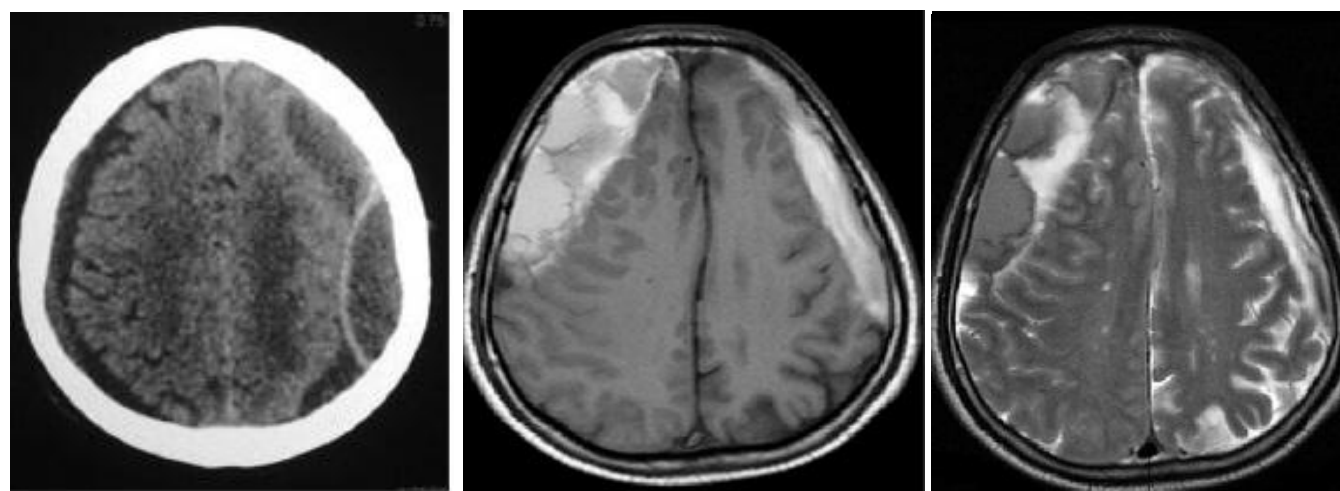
Pre op CT Brain of OCS DH.*
